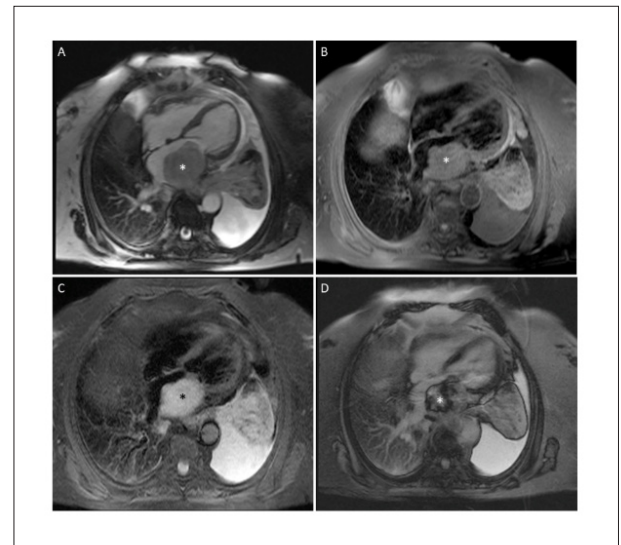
Cardiac magnetic resonance imaging. (A) T1-weighted image revealing an isointense mass (*). (B) T2-weighted image with the mass appearing as hyperintense. (C) Contrast uptake in first-passage sequences. (D) Heterogeneous late gadolinium enhancement.
